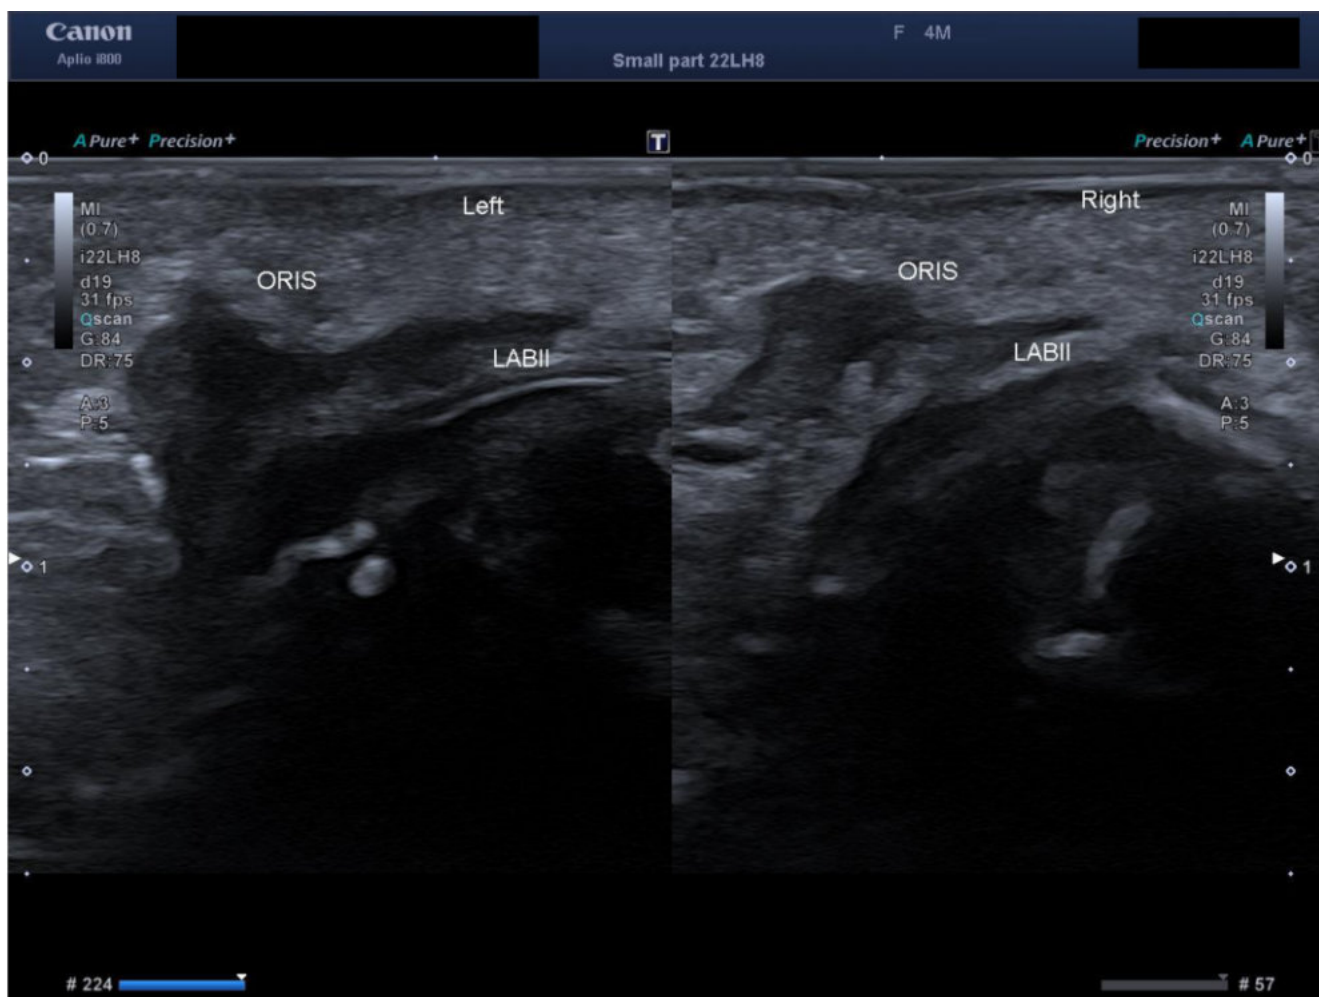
Ultrasound finding of thinner and smaller right depressor angularis oris muscle (2.4 mm) compared to the normal left depressor angularis oris muscle (3.2 mm).
